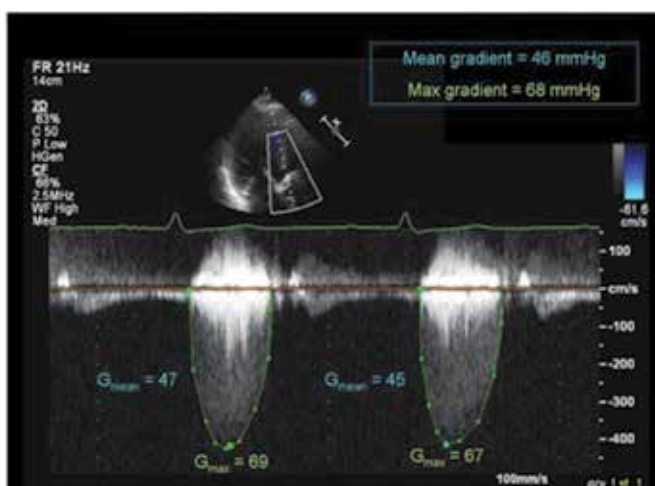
To obtain the mean gradient, "trace" is used to trace the envelope of the aortic outflow. A mean aortic valve gradient greater than 40 mm Hg on Doppler echocardiography is indicative of severe AS.
